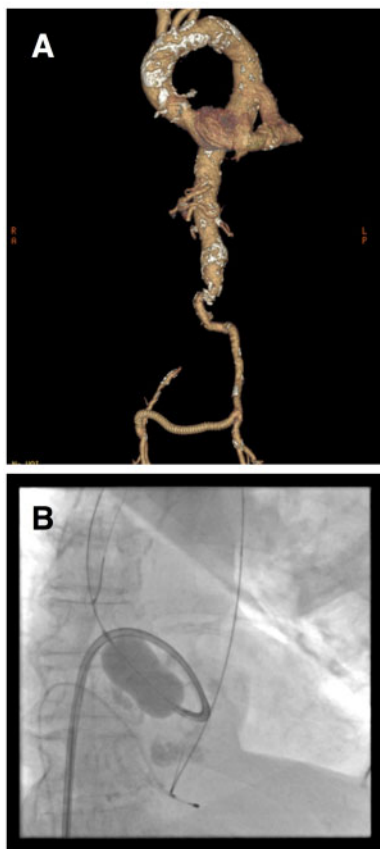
(A) A computed tomography angiography of aorta and iliac arteries. A total occlusion of the right limb of Y-graft, and a patent femoro-femoral bypass can be seen. An apico-aortic conduit which connects a left ventricular apex and a thoracic descending aorta is also visualized. (B) A fluoroscopy image during an antegrade transseptal balloon aortic valvuloplasty using a 22-mm Inoue balloon via a right femoral vein approach. (C) The haemodynamics before and after balloon aortic valvuloplasty.
